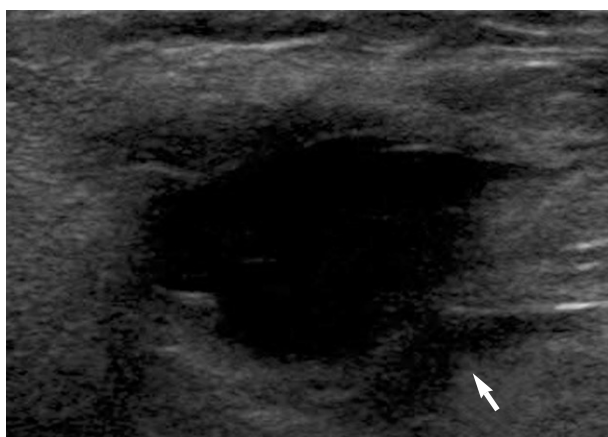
The ultrasonography shows an irregular cystic lesion in the upper outer quadrant of the right breast (arrow).
